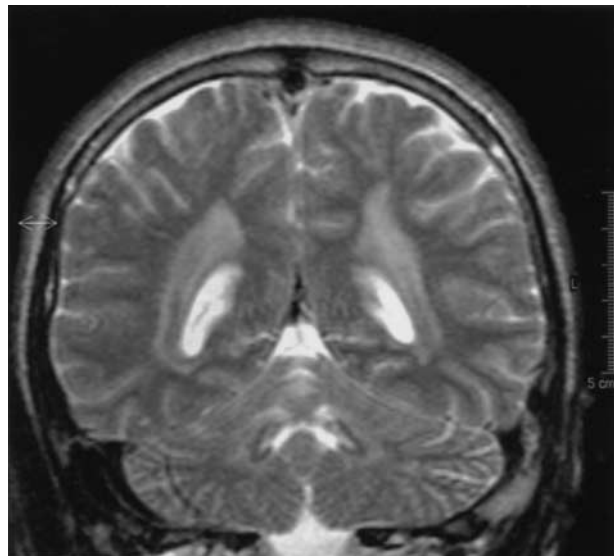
(A) Axial T2-weighted (TR = 4530 ms, TE = 100 ms) image shows diffuse hyperintense lesions in white matter. (B) These lesions are more prominent in posterior parietal white matter on coronal T2-weighted image (TR = 4530 ms, TE = 100 ms), which also shows similar lesions in cerebellar white matter.
